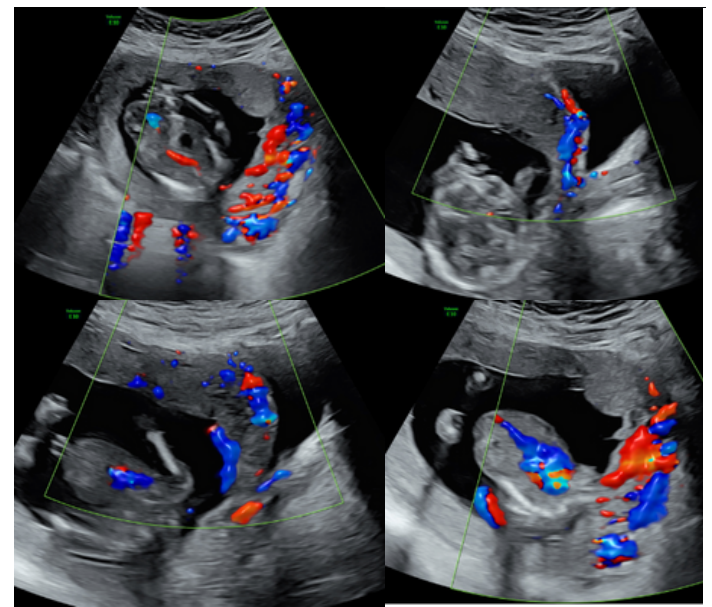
Ultrasound at 15+5 showing anterior low lying placenta with lacunae and placental bed hypervascularity near the bladder
